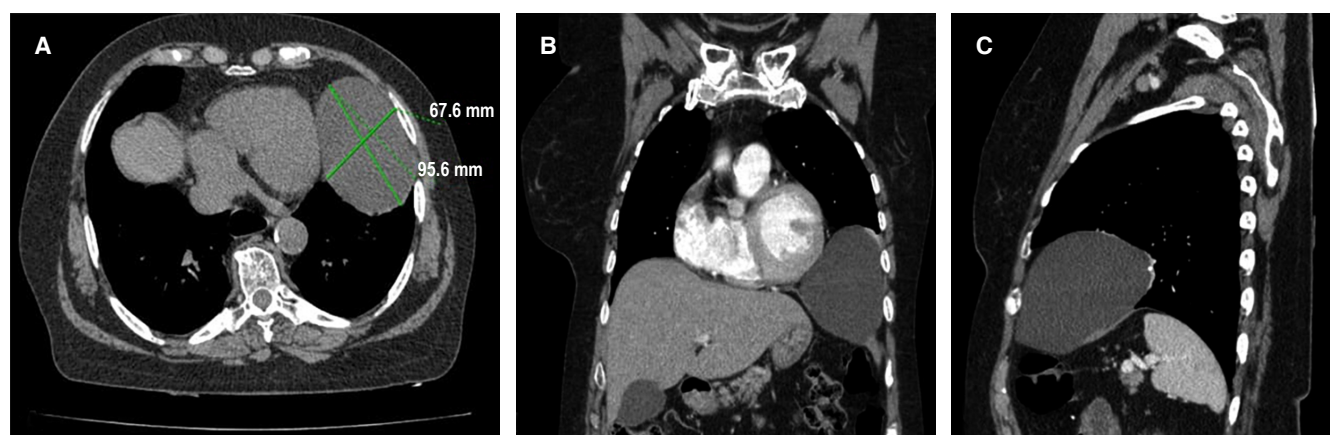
A) Plain axial computed tomography scan showing a cystic lesion in the left pericardial region measuring 6.76 × 9.56 cm, with an approximate volume of 290 ml. B-C) Contrast-enhanced coronal and sagittal computed tomography scans showing the presence of a pericardial cyst over the left costal diaphragmatic sinus.
